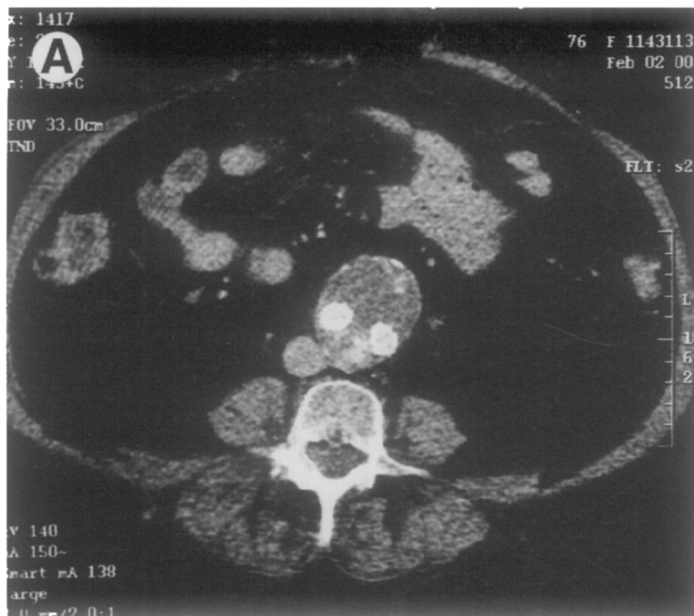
Type III endoleak. (A) Contrast-enhanced axial CT scan through the abdomen shows a leak in the posterior aneurysm sac. (B and C) Digital subtraction angiography shows the leak arising from within the left limb of the graft. This must therefore be related to a fabric tear.
